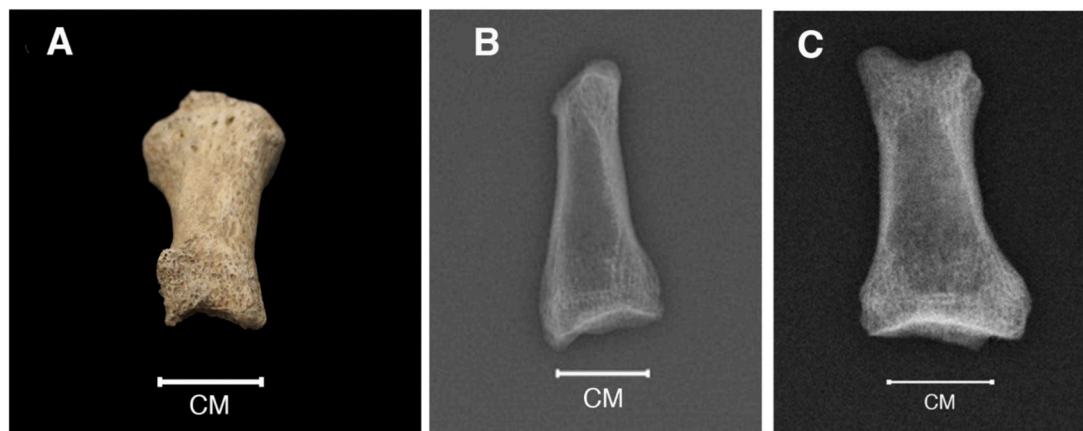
A) Detail of bone destruction on the distal end of the first proximal phalanx of the UF 702 UE 7019 right hand (male, indeterminate age at death). Palmar view. B) Sagittal view radiograph of the right first proximal phalanx. Bone destruction can be noticed on its distal end, which affects the joint surface. C) Frontal view radiograph.
